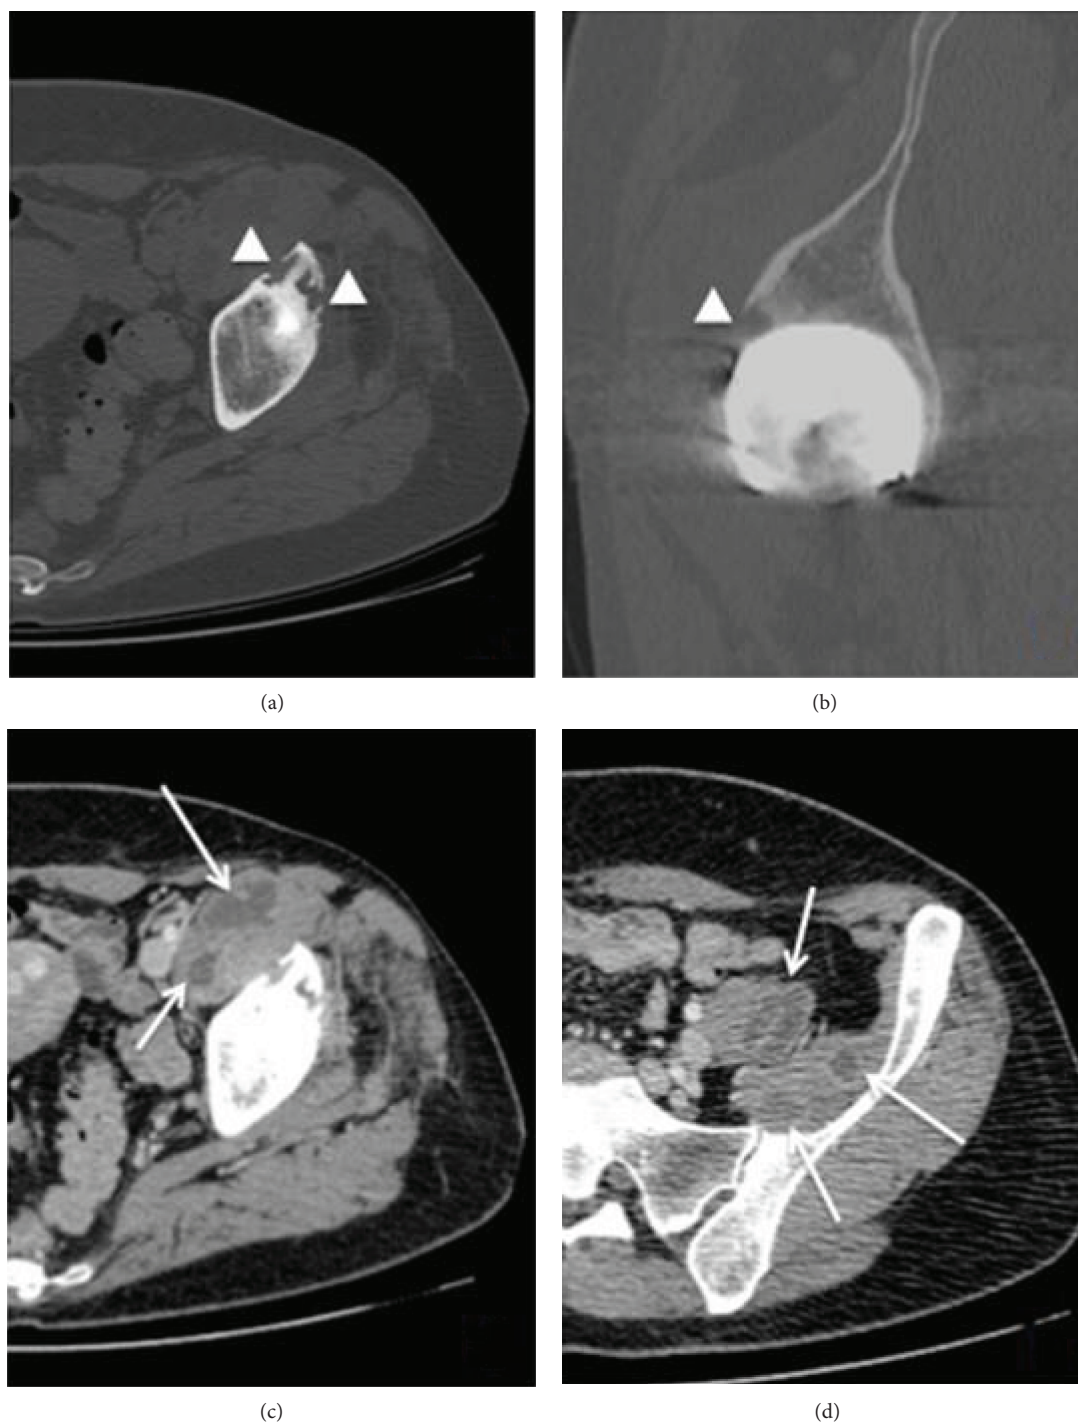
Computed tomography of the left hip: axial (a) and sagittal (b) views show periprosthetic osteolytic lesions (arrow head) in the anterior acetabular roof. Axial views (c, d) show a polylobate cystic lesion in the retroperitoneum compromising the left iliopsoas muscle with white arrows.
